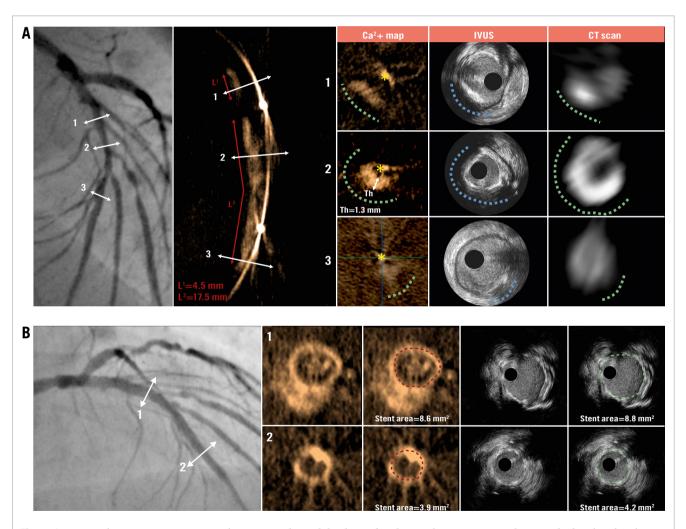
Pre- and post-stenting LAD analysis. A) Multimodal calcium burden analysis in an LAD lesion. The head-to-head comparisons between Ca²⁺ mapping, IVUS, and CT scan are presented for different cross-sections within the LAD (1, 2 and 3). The X-ray-based methods and IVUS analyses displayed concordant results for calcium radial extent (green dashed lines for Ca²⁺ mapping and CT scan; blue dashed line for IVUS; yellow asterisk indicates the position of the wire), with a maximal arch of 270° (mid-LAD/section 2). In addition, Ca²⁺ mapping provided evaluation of calcification thickness and longitudinal extent. B) Post-stenting analysis by 3DStent and IVUS. The head-to-head comparisons between 3DStent and IVUS are presented for the proximal (1) and distal (2) parts of the stent. Each cross-section presents raw images and stent area measurement. Ca²+: calcium; CT: computed tomography; IVUS: intravascular ultrasound; LAD: left anterior descending artery; Th: thickness
